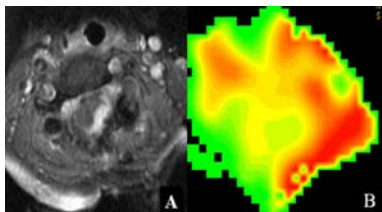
A case of ependymoma. A: Axial T1-weighted post-contrast image; B: rCBV images. The lesion at the C2-3 level left of the cervical spinal cord enhanced on the post-contrast T1-weighted image, while the lesion showed increased perfusion (red signal) on the rCBV image.
